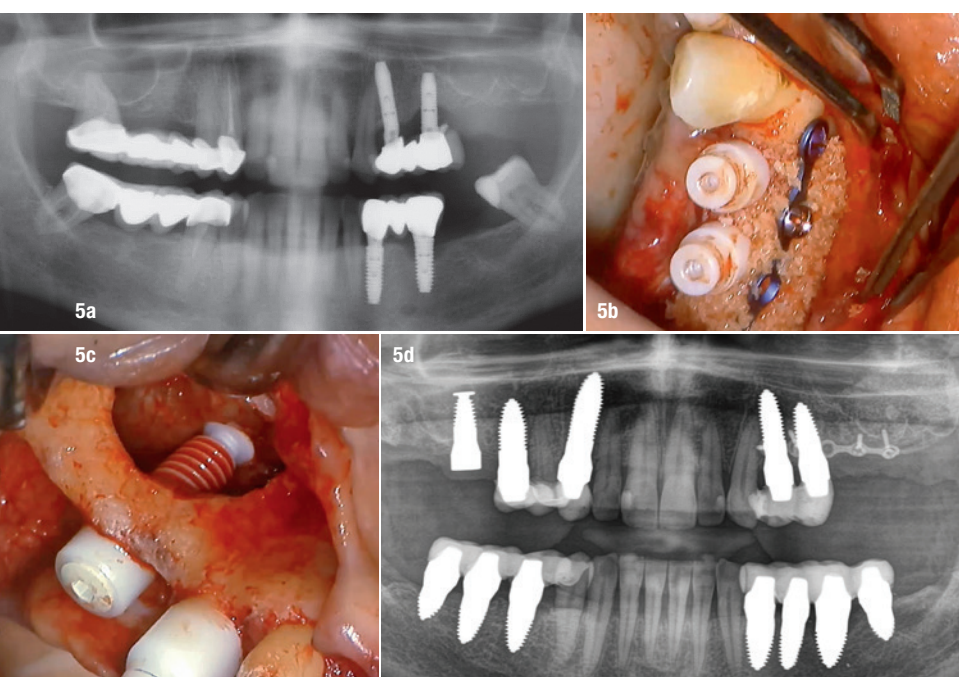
Pre-op panoramic radiograph (a), intra-oral image after fixation of the osteosynthesis plate and bone augmentation in regions #25–27 (b), intra-oral image after placement of a sinus implant into region #26 (c), post-op panoramic radiograph after implant placement in the upper and lower jaws (d).
